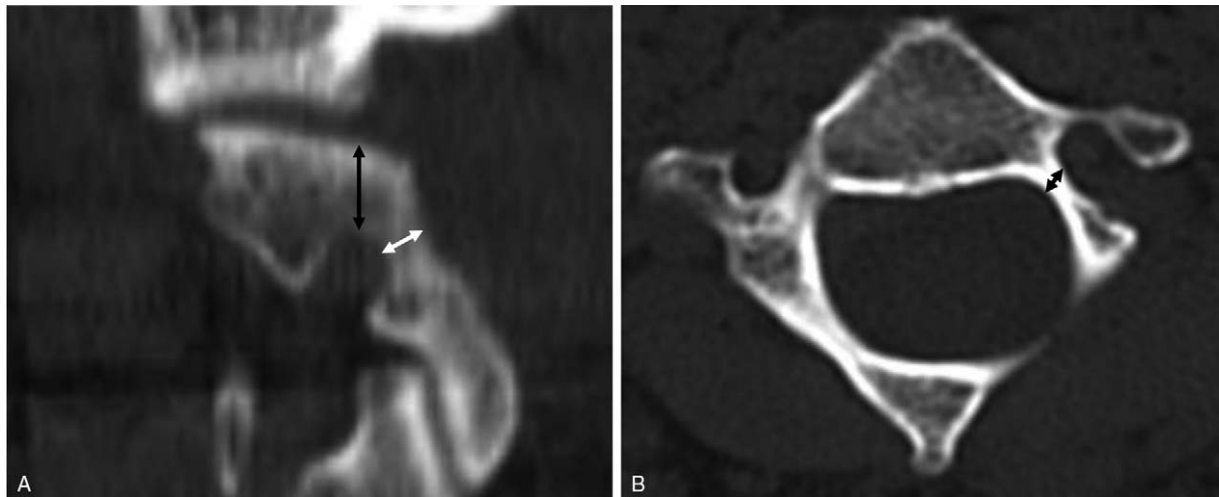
The three radiologic measurements used to define the presence of a high riding vertebral artery (HRVA) on cervical computed tomographic (CT) images. (A) A parasagittal CT image showing heights of the superior pars (black arrow) and isthmus (white arrow). (B) Axial CT image showing a narrow left C2 pedicle (black arrow). HRVA was defined as the superior pars height of ≤ 2 mm, and/or isthmus height of ≤ 5 mm, and/or pedicle width of ≤ 4 mm.
